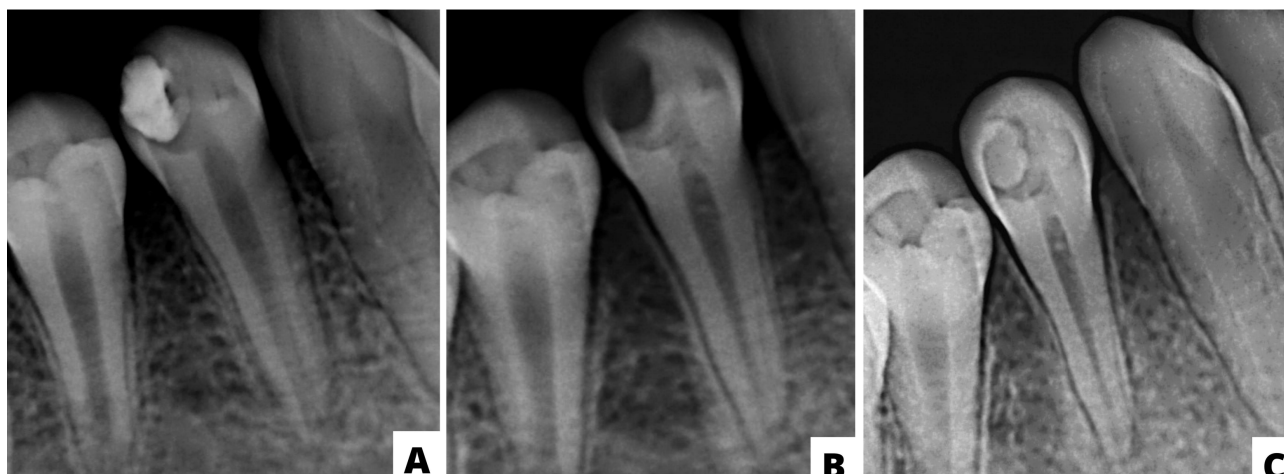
A. Periapical region without radiological changes. B. Location of pulp exposure. C. Periapical radiography after eleven months without the need of endodontic treatment.
